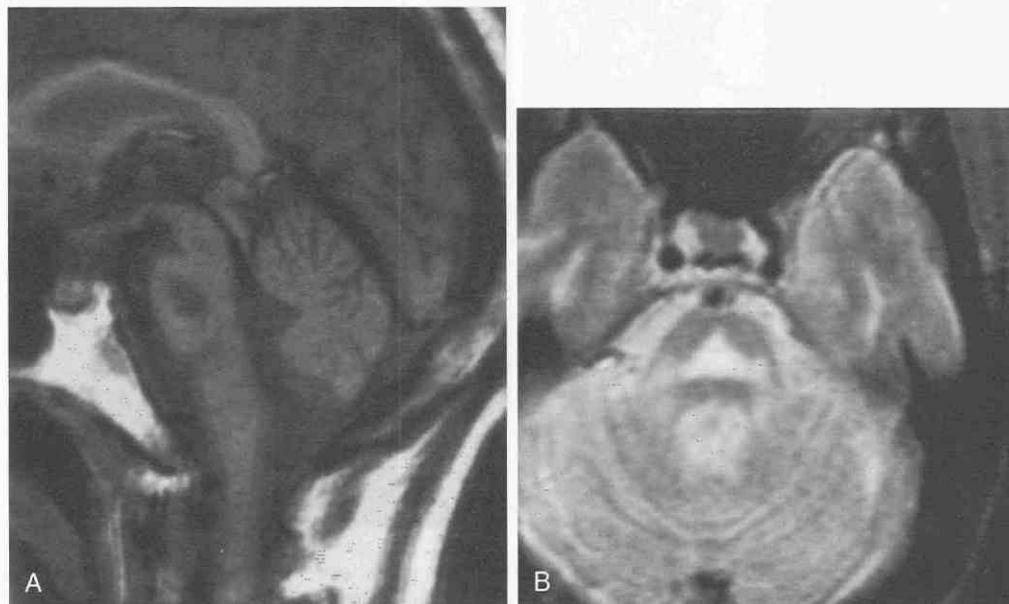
Central pontine myelinolysis (CPM) in a 56-year-old man. A, Midsagittal T1-weighted cranial MR image shows a triangular hypointense lesion in the midpons. B, Axial T2-weighted MR image at the midpontine level. Note the classic trident-shaped hyperintense lesion, characteristic of CPM.
